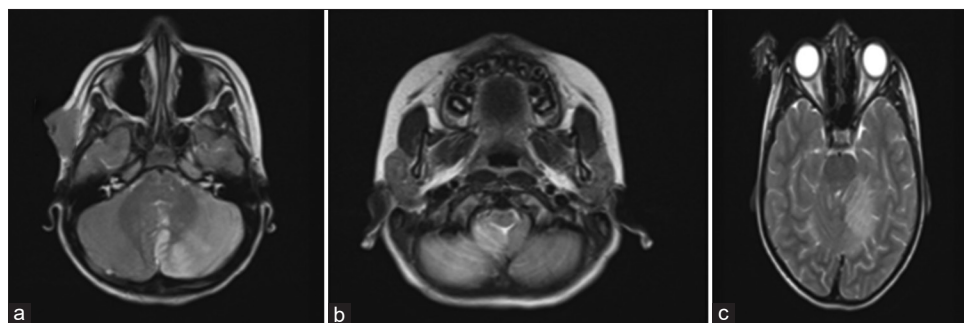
Magnetic resonance imaging brain contrast showing (a) T2 hyper intensities involving the territories of bilateral anterior inferior cerebellar artery; (b) Bilateral posterior cerebral artery; (c) Left superior cerebellar artery
